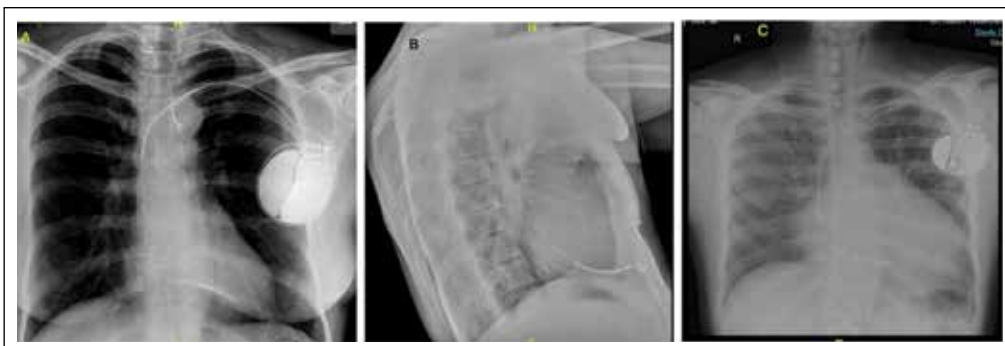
RV apical pacing lead (Dual coil AICD lead) in frontal and lateral chest radiographs (A, B respectively), A dual chamber AICD in situ (C).
